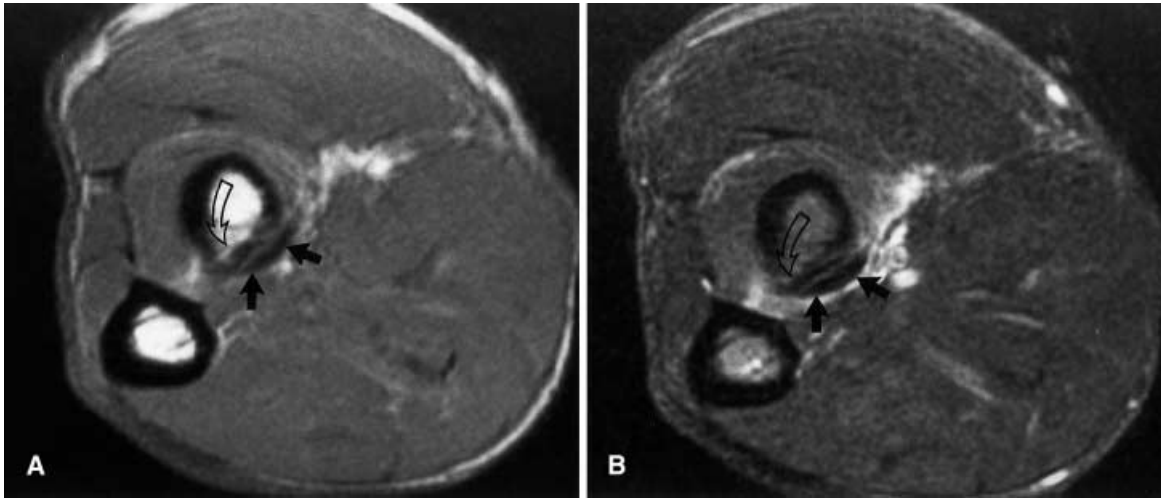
A 50-year-old man with a surgically proven partial tear of the distal biceps tendon. A Transverse T1-weighted (400/14) spin-echo and B transverse T2-weighted fat-suppressed (3166/76) fast spin-echo MR images obtained at the level of the radial tuberosity (*curved arrows*) demonstrate thickening of the distal biceps tendon with increased signal and intratendinous tear at its insertion at the radial tuberosity (*arrows* in A and B). The extent of the tear was graded as 30%
